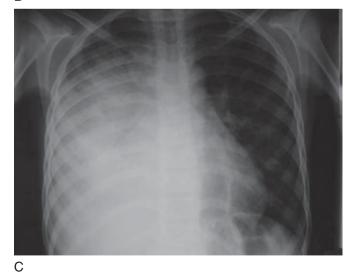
Immune reconstitution in a child with undiagnosed tuberculosis (TB) started on HAART. A, Chest radiograph prior to HAART initiation when a TB work-up was negative. B, Chest radiograph I month into HAART therapy showing development of right-sided disease. C, Chest radiograph 2 months into HAART therapy showing extensive right-sided disease and compression of the right bronchus. A gastric lavage culture obtained prior to initiating HAART then grew Mycobacterium tuberculosis and the tuberculin skin test became positive.
